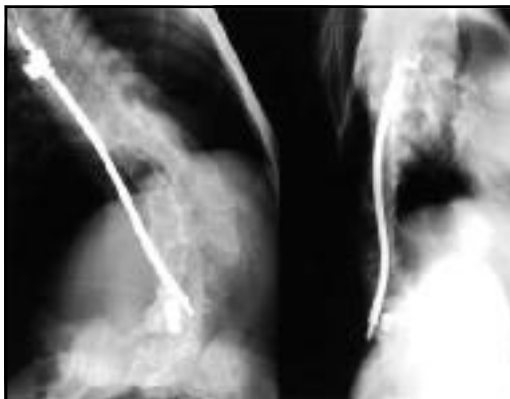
X-ray of thoracolumbar spine showing a detachment of the wire in a patient with rigid spine syndrome.
